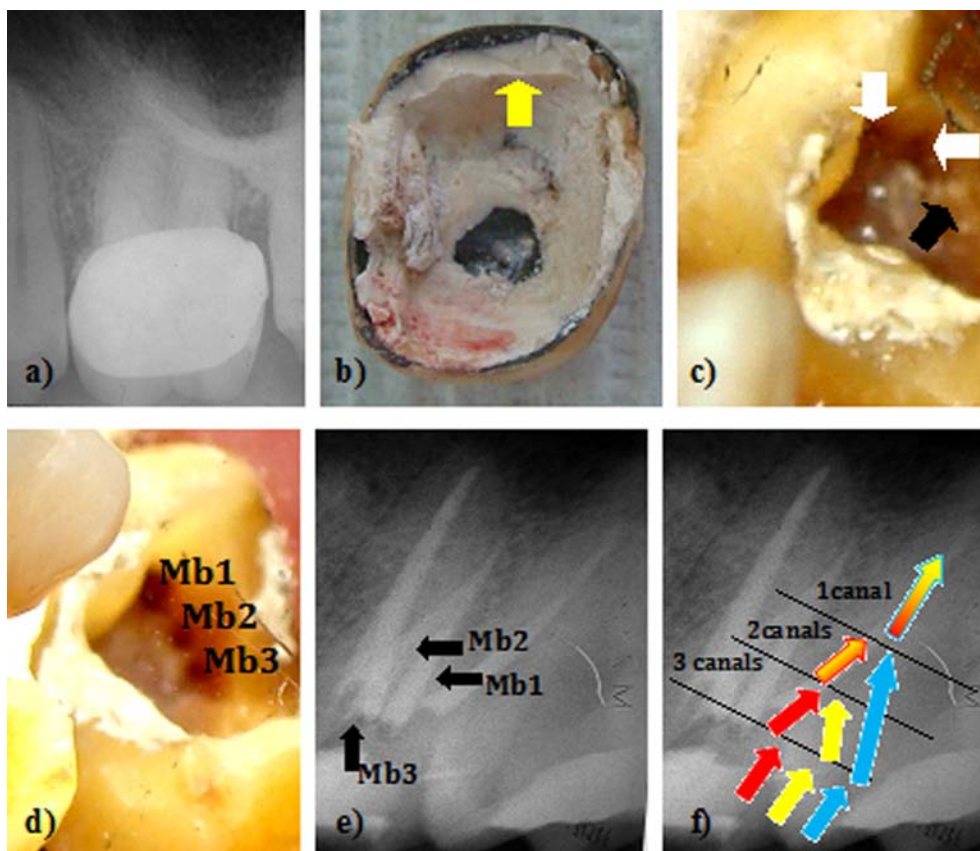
a) Preoperative radiograph. b) Thick layer of cement under-surface of the crown (yellow arrow). c) Photograph showing the Mb1 and Mb2 (white arrows). Mb3 was located under the dentin shelf (black arrow). d) The 3 Mb canal orifices following coronal enlargement. e) Postoperative radiograph. f) 3-2-1 root canal configuration (Blue arrow: Mb1, Yellow arrow: Mb2, Red arrow: Mb3). Mb3 joins Mb2 at the coronal third, and Mb2 joins Mb1 at the middle third ending by one canal.
